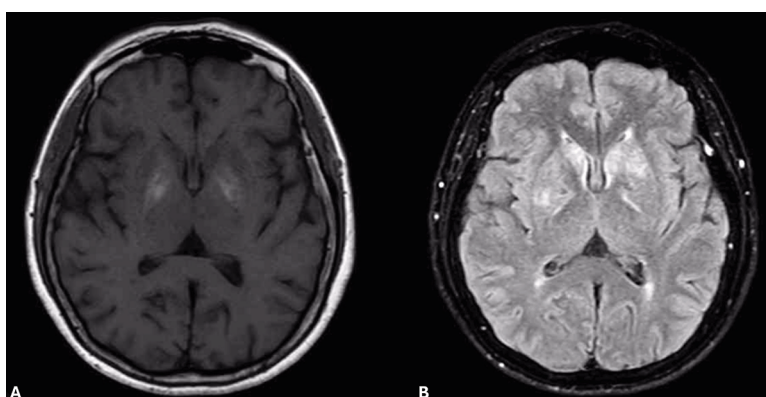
Brain magnetic resonance imaging. (A) Axial T1-weighted image demonstrating bilateral hyperintensity of the globus pallidi. (B) Axial T2-weighted fluid-attenuated inversion recovery sequences showing symmetrical hyperintensity in the bilateral caudate nuclei, putamina, and some parts of the globus pallidi without contrast enhancement. These findings are supportive of mitochondrial encephalopathy.
